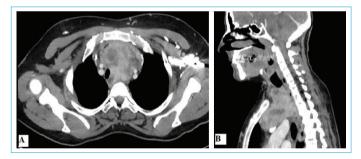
Computed tomography images of a substernal goiter case. (a): Axial section, (b): Sagittal section.
